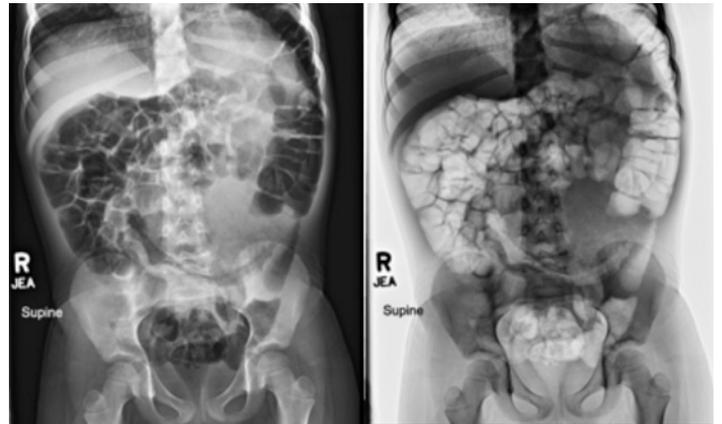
is an Abdominal/KUB AP X-ray revealing a large soft tissue density with numerous tiny lucencies is seen within the left abdomen.
